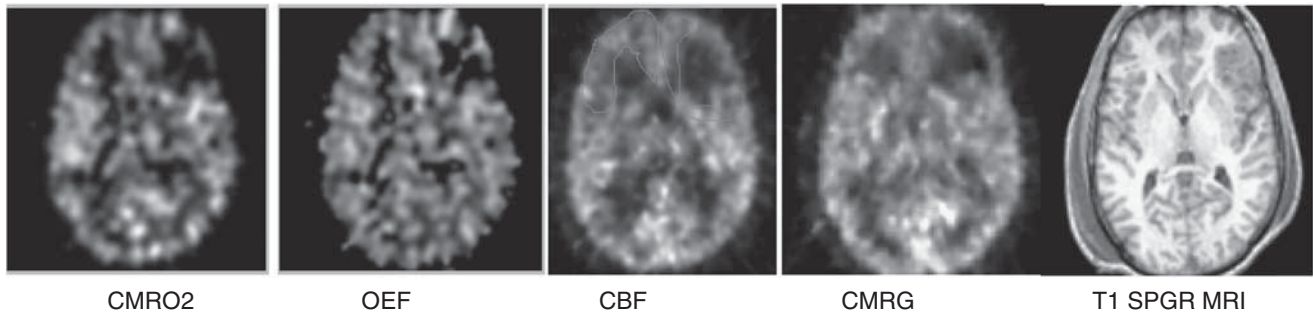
Comparison of coregistered acute MRI and PET images used for analysis. Regions of interest (ROIs) for each lobe were hand drawn for PET and MRI. An example of a single-slice ROI of the frontal lobe was drawn on the cerebral blood flow image to exclude the contusion on the left. CMRO₂, cerebral oxidative rate of oxygen; OEF, oxygen extraction fraction; CBF, cerebral blood flow; CMRG, cerebral metabolic rate of glucose.
